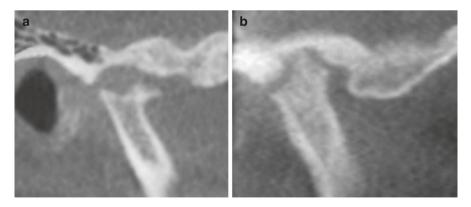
A TMJ affected by rheumatoid arthritis (RA) may be difficult to differentiate from degenerative joint disease radiographically and should be assessed clinically as well. Some of the radiographic clues for RA are irregular and pronounced destruction of the articular surfaces (a). End-stage RA may result in fibrous or bony ankylosis of the joint (b) (Courtesy, D, Hatcher, DDS)
